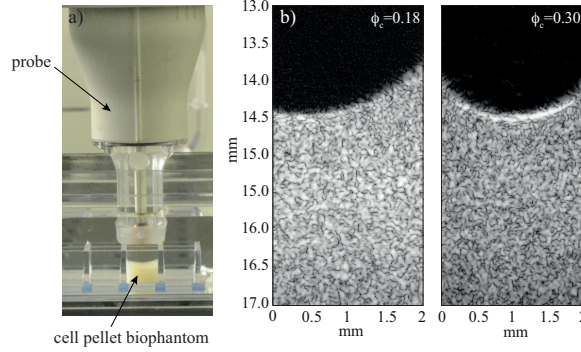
(a) Sonde ultrasonore et bio-fantôme de cellule immergé dans une solution saline. (b) Images B-mode de bio-fantômes de cellules pour des concentrations de 0.18 et 0.30 avec une sonde de fréquence centrale 20 MHz.
